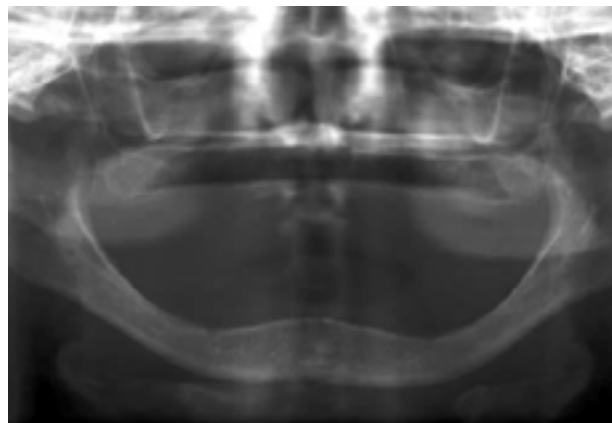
A panoramic radiograph and B. Intraoral view of a patient with severe ridge resorption following tooth loss
